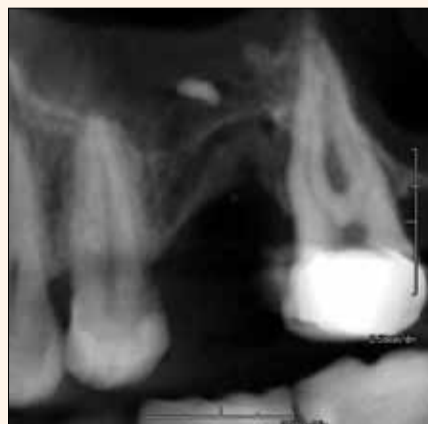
Periapical does not show the sinus anatomy or the width of the bone.
